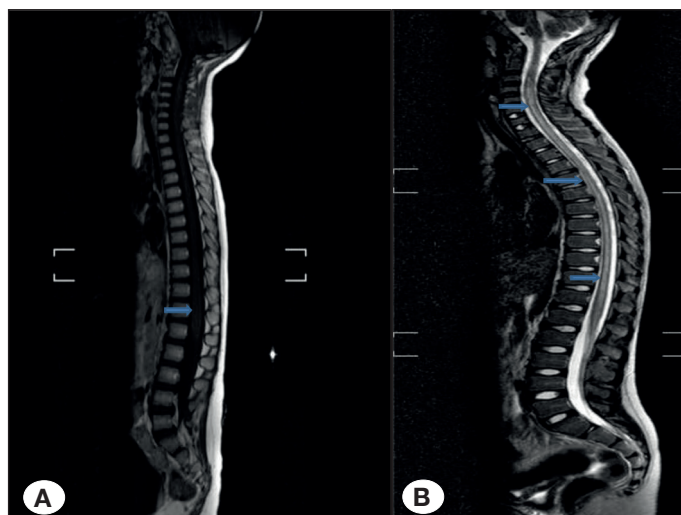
A) Pial enhancement in the distal thoracic plane. B) Sagittal longitudinal MR image showed increased signal in the gray matter starting from the C2 inferior end plate level to the subject in the whole spinal cord and expansion due to edema in the cervical.
